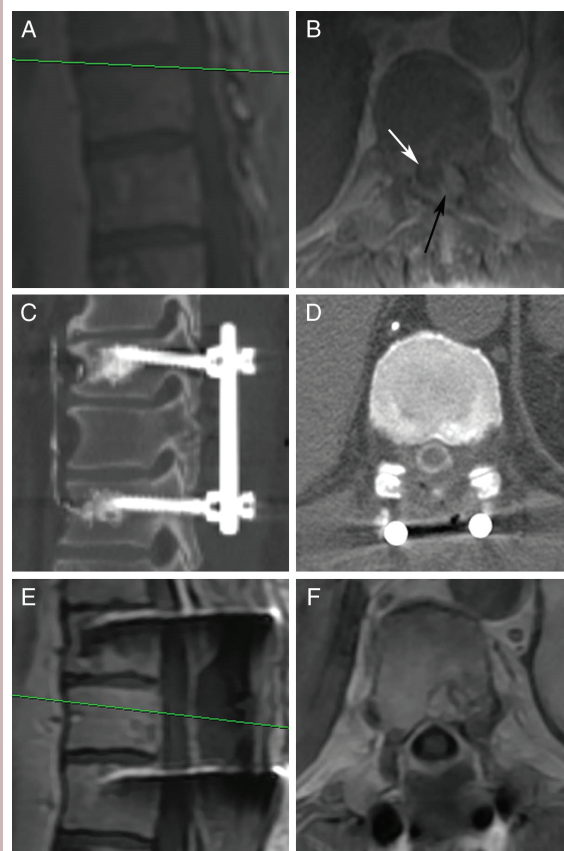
A 61-year-old man with metastatic renal cell carcinoma presented with left-side subscapular pain that worsened with recumbency consistent with mechanical instability. A, Sagittal and B, axial T1 weighted postcontrast MRIs of the spine revealed epidural spinal cord compression grade 3 of the spinal cord (white arrow) at T10 from a metastatic tumor (black arrow). The patient was treated with separation surgery followed by stereotactic body radiotherapy. C, Sagittal and D, axial images from a CT myelogram of the spine performed 5 days after surgery for radiation planning show pedicle screw fixation at T9 and T11 with cement augmentation as well as circumferential decompression of the spinal cord with reconstitution of the cerebrospinal fluid space. Three-month posttreatment E, sagittal and F, axial T1-weighted postcontrast MRIs of the spine confirm local control.
